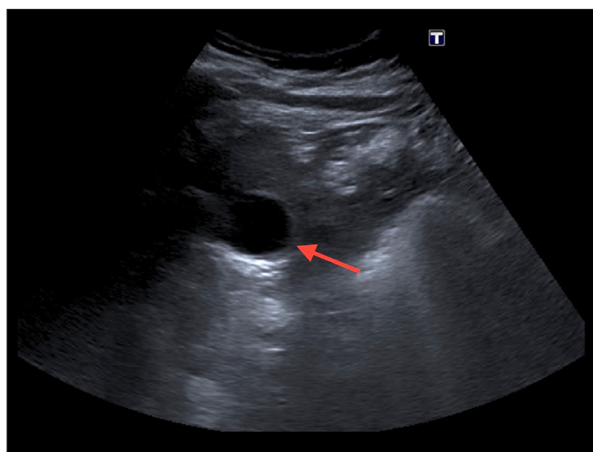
Ultrasound image of Bosniak 2F cyst in left kidney (red arrow).
